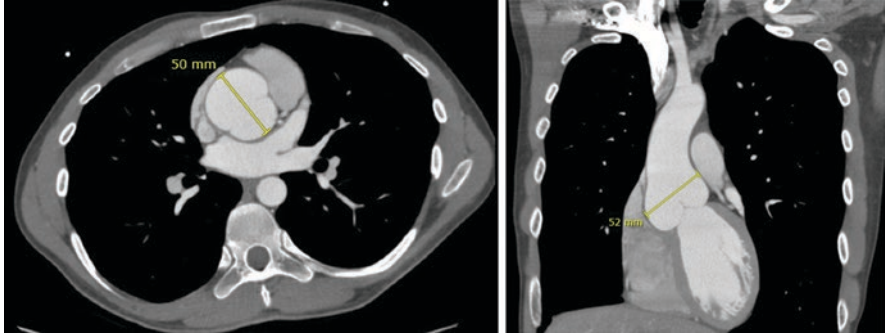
Axial and sagittal contrast CT scan showing an isolated aortic root aneurysm
